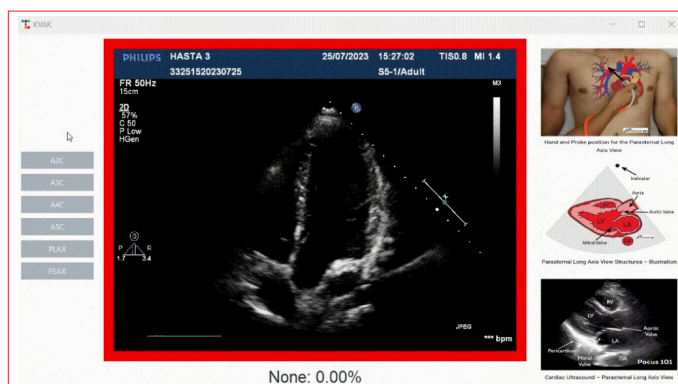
A5C measurement to improve visualization and user-friendliness, we developed a dedicated application for our model. In this application, the user can select the desired echocardiographic view using the buttons on the left panel. On the right side, we included reference images to assist students while reviewing the selected view. The central area displays the real-time echocardiographic image. A guiding frame appears around the image: green if the correct view is approached, and red if the current view is far from the target, helping guide the user toward the correct position. At the bottom of the interface, the model's prediction and its confidence percentage are displayed. The video format of the file could not be loaded. A measurement video is available. It can be sent upon request.
